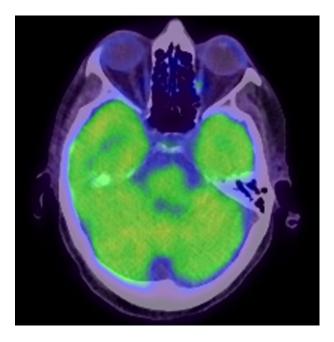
Axial ¹⁸F-FDG PET/CT post chemotherapy showing return to normal metabolic activity of bilateral cavernous sinus.
